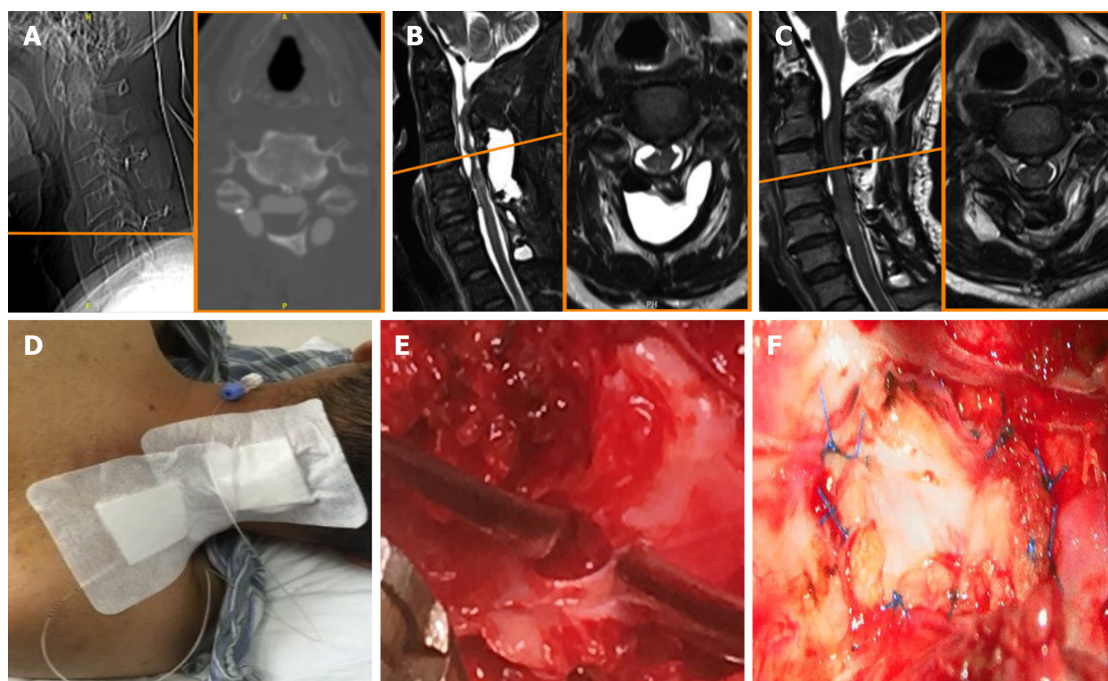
Imaging examination and treatment at our hospital. A: Computed tomography myelography revealing that the defect of dural-arachnoid was located at the C5 level and close to the lower edge of the fixed plate; B: Sagittal and axial view of cervical magnetic resonance imaging before pseudomeningocele drainage; C: Sagittal and axial view after pseudomeningocele drainage revealing a significant decrease in the cystic volume; D: The patient undergoing pseudomeningocele drainage; E: Intraoperative photograph demonstrating the dural-arachnoid defect; F: Dural-arachnoid defect was repaired with autologous fascia.
